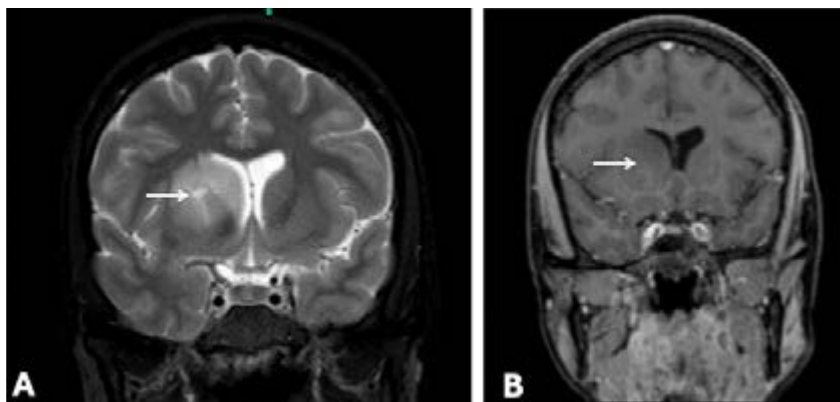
MRI of a 31-year-old woman with a one-week history of severe headache and nuchal rigidity. Coronal T2WI sequence (A) and contrast-enhanced coronal T1WI sequence (B), showing a large frontal periventricular lesion involving the head of the caudate nucleus (arrows), together with a mass effect, demonstrating hyperintensity on T2WI and no enhancement on contrast-enhanced T1WI.
